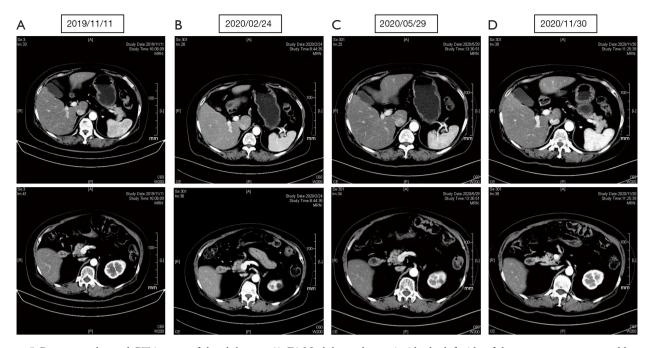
Contrast-enhanced CT images of the abdomen. (A-D) Nodules and mass inside the left side of the greater omentum and between the stomach and abdominal aorta were not obvious. Two small nodules almost disappeared outside the liver outline in the capsule of the right posterior lobe of the liver. CT, computed tomography; A, anterior; R, right; L, left; P, posterior.
